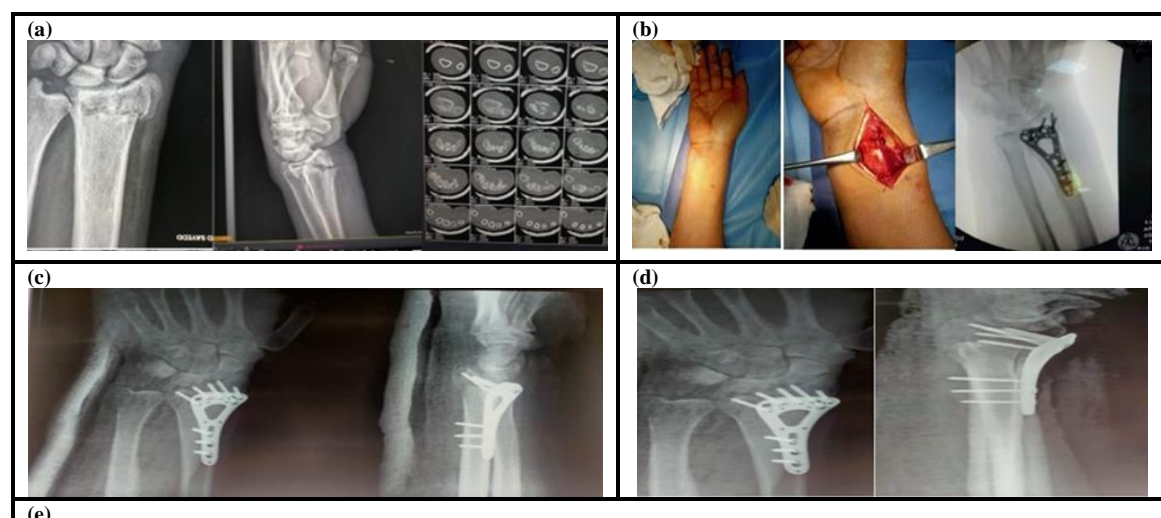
A 39 years old male patient with right dominant distal radius fracture for fixation by polyaxial plate; (a) preoperative x-ray and CT; (b) intraoperative photos; (c) 1 week postoperative; (d) 6 months post-operative; and (e) post-operative ROM.
